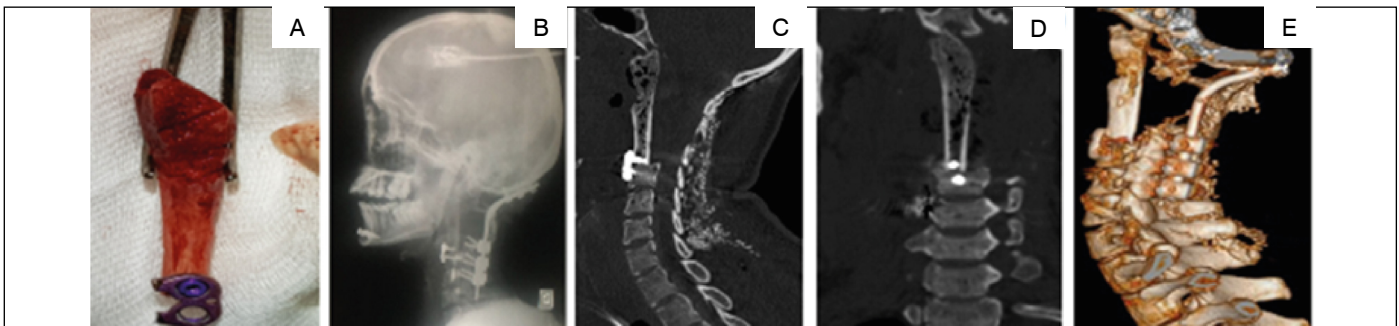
(case 4): A – Fibular allograft. B, C and D – X-ray and CT scan showing anterior CVJ reconstruction. E – 3D CT scan.
